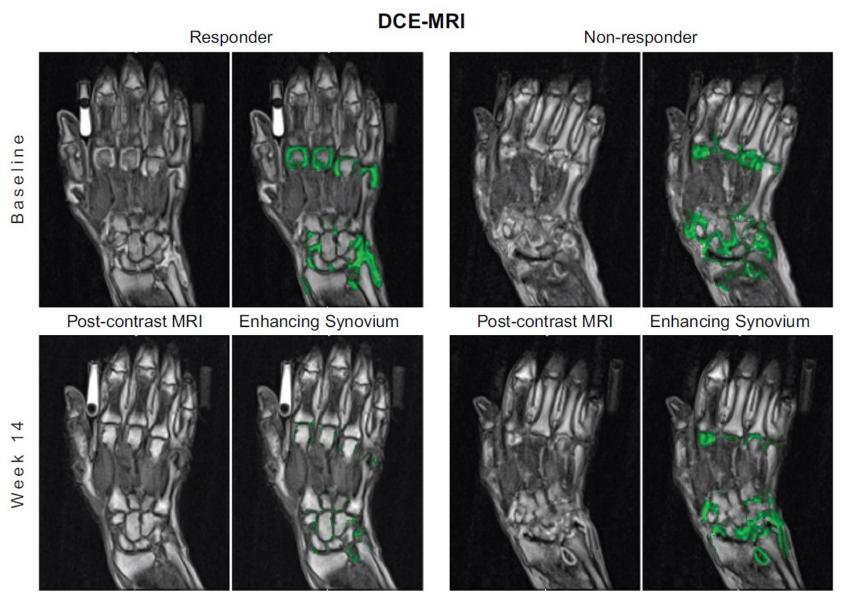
Baseline vs Week 14 DCE-MRI. Enhancing Synovium (green regions of interest) decreased dramatically from baseline to Week 14 in a clinical responder treated with infliximab (left), but was largely unchanged in a non-responder treated with placebo (right). Responder was defined as change from baseline in DAS28(CRP) >1.2 and non-responder as <0.6.
